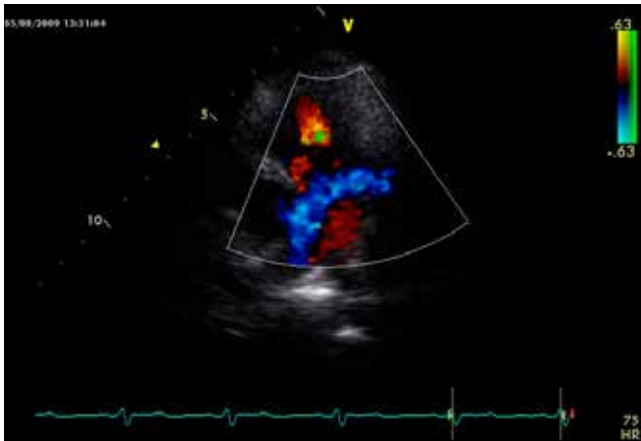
Echocardiography. Apical four-chamber view. Colour Doppler image documenting collaterals between the left and right coronary arteries in the apical region
